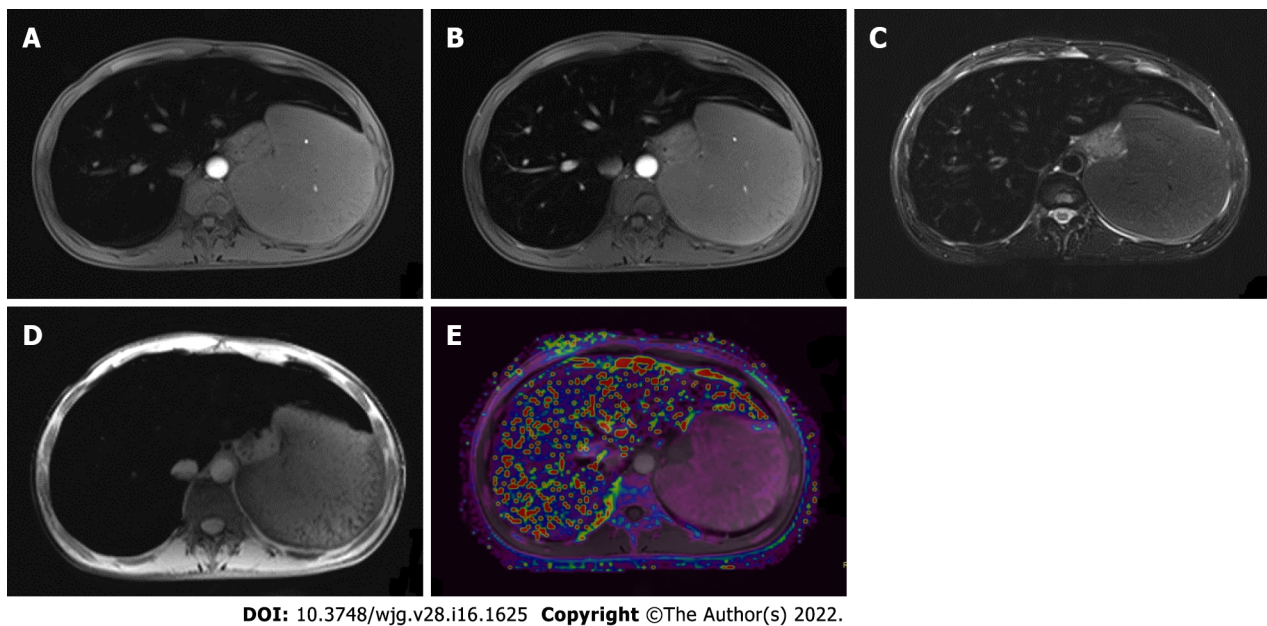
Magnetic resonance images of a 26-year-old man with hemochromatosis. Pre-contrast T1-weighted image (A), portal venous phase T1-weighted image (B), T2-weighted image (C), and SWI image (D) showed signal intensity in liver parenchyma, while R2* mapping (E) shows increased signal intensity in the liver, demonstrating severe iron overload. R2: Relaxation rate.
